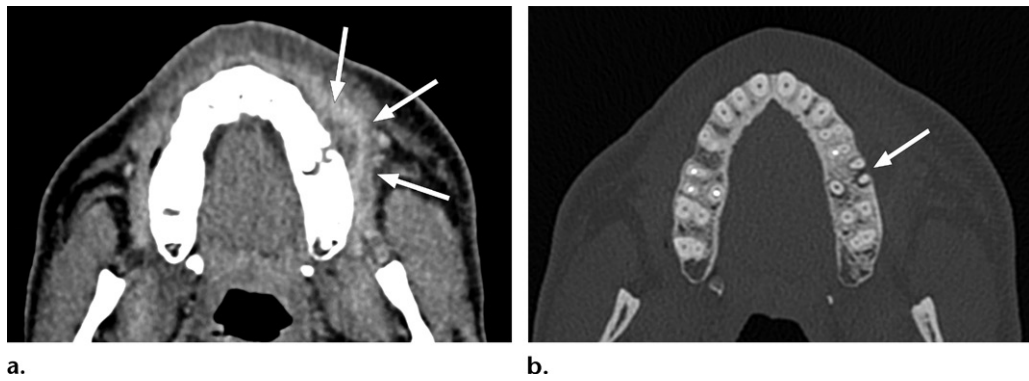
Subperiosteal abscess. (a) Axial contrast-enhanced CT image (soft-tissue window) shows a hypodense fluid collection with peripheral enhancement and stranding of the adjacent fat tissues (arrows). (b) Axial CT image (bone window) demonstrates that the collection is continuous with periapical disease and erosion of the vestibular cortical bone (arrow).
